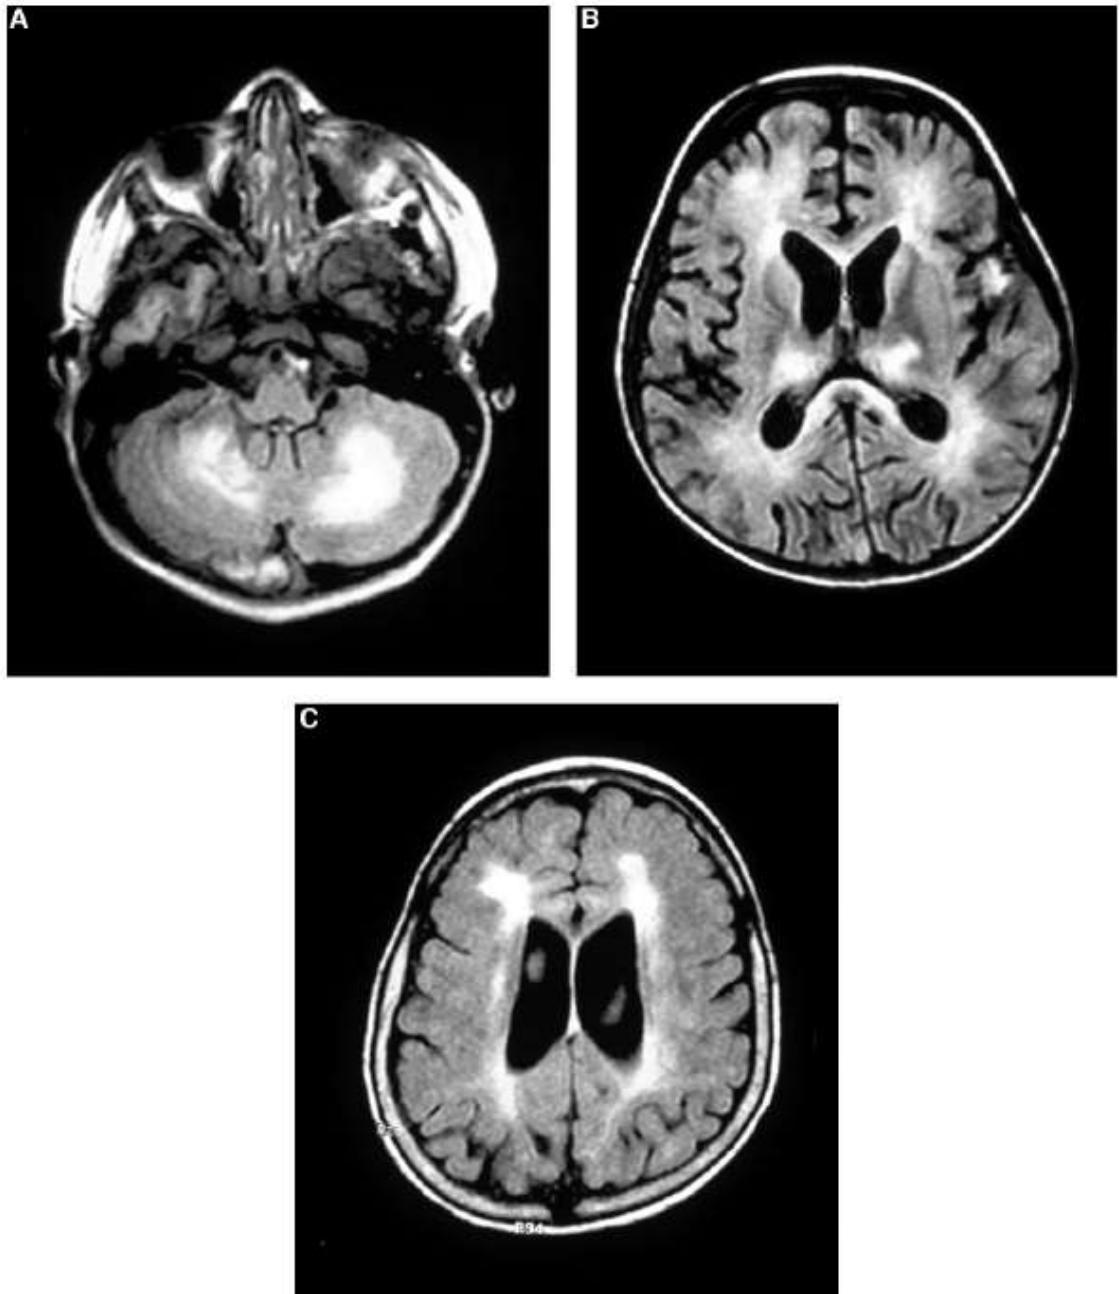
Neuroimaging of human brain with *B. procyonis* NLM. (A) In acute NLM, an axial-flair magnetic resonance (MR) image (at the level of the posterior fossa) demonstrates an abnormal hyperintense signal of cerebellar white matter; (B) an axial T2-weighted MR image (at the level of the lateral ventricles) demonstrates an abnormal patchy hyperintense signal of periventricular white matter and basal ganglia; (C) an axial T2-weighted MR image (at the level of the lateral ventricles) of a patient with subacute/chronic NLM demonstrates residual abnormal hyperintense signal of the periventricular white matter, loss of white matter volume, and dilation of ventricles and sulci, consistent with generalized cerebral atrophy.
